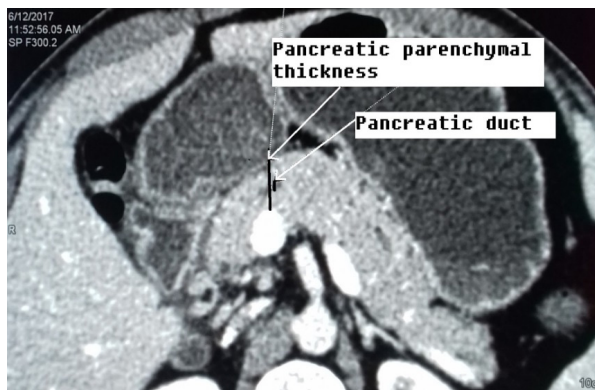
Axial CT scan in portal venous phase measuring pancreatic parenchymal thickness and pancreatic duct diameter at the neck of the pancreas.
